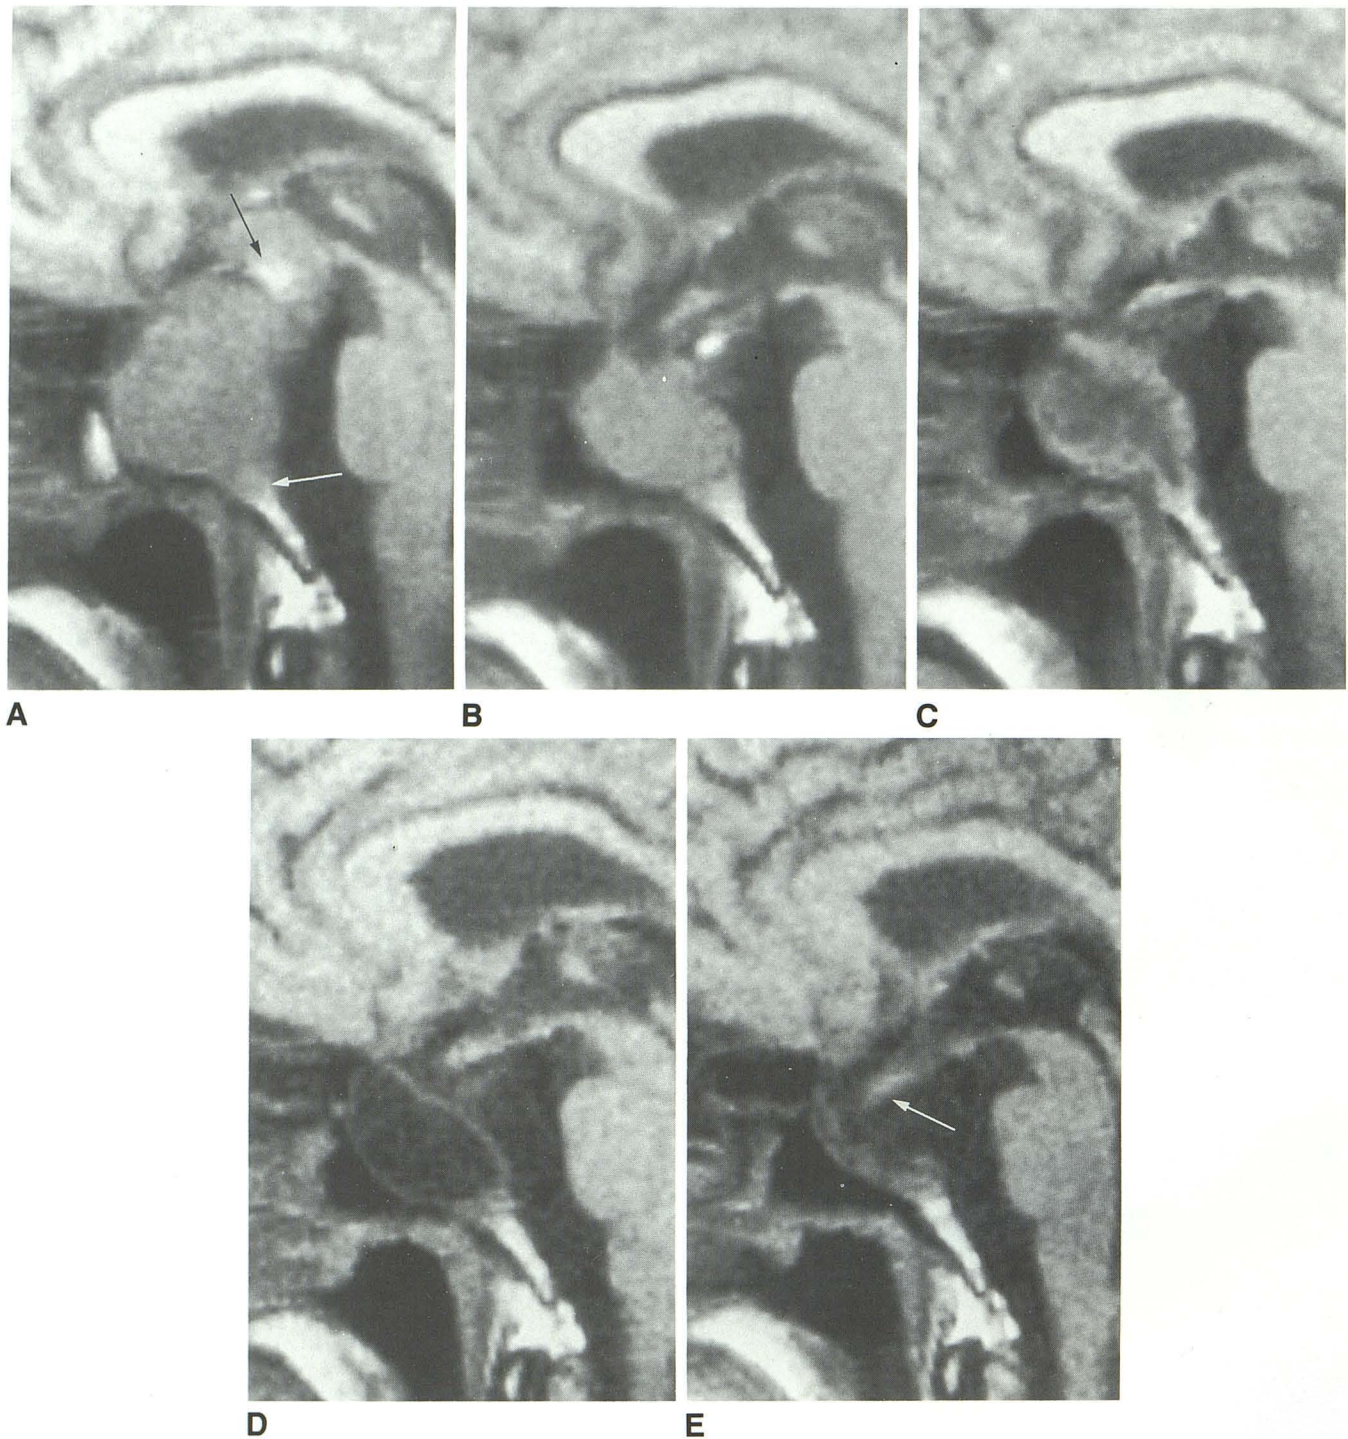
Patient 5. T1-weighted (500/30) sagittal images.
